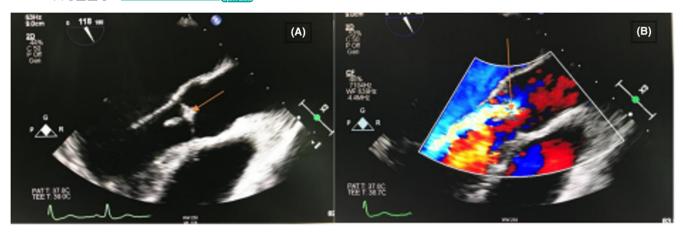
Transesophageal echocardiogram on the first admission in August 2020. A transesophageal echocardiogram shows large vegetation on the left aortic cusp protruding into the left ventricular outflow tract with moderate aortic regurgitation. The orange arrow in Figure A shows the vegetation, and the orange arrow in Figure B shows the aortic regurgitation.
